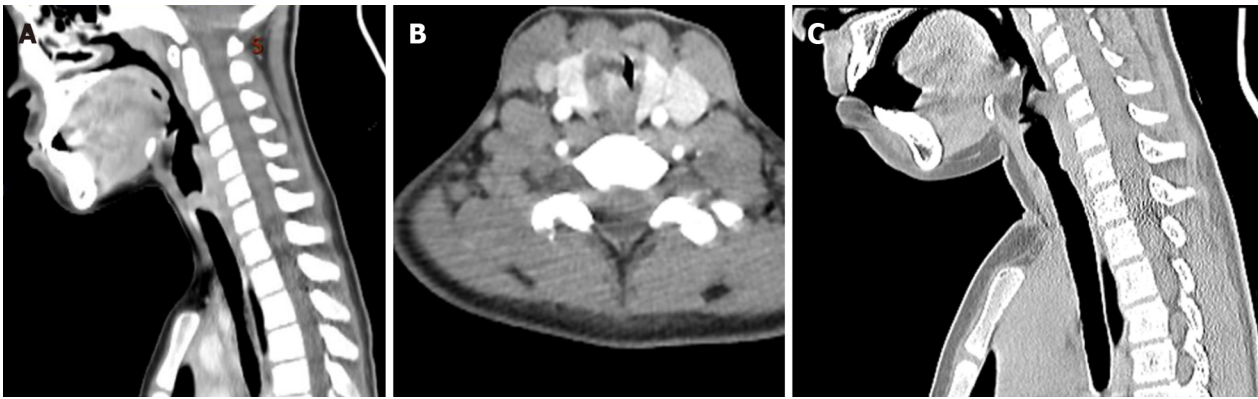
Preoperative and postoperative imaging. A: Computed tomography (CT) revealed a mass occluding about 90% of the tracheal lumen; B: Contrast-enhanced CT a soft tissue mass with obvious enhancement on the right posterolateral wall of the trachea; C: CT indicated a slight protrusion at the position of the incision.
